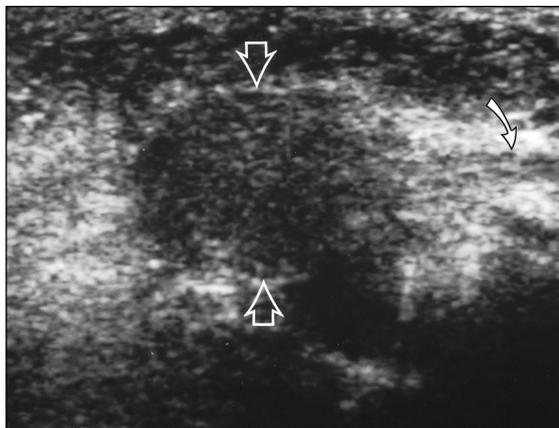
24-year-old woman with surgically excised Morton's neuroma. Preoperative longitudinal 5-12 MHz sonogram shows discrete oval hypoechoic mass (*open arrows*), lying between metatarsal heads. Digital nerve (*solid arrow*) can be seen proximal to mass.
